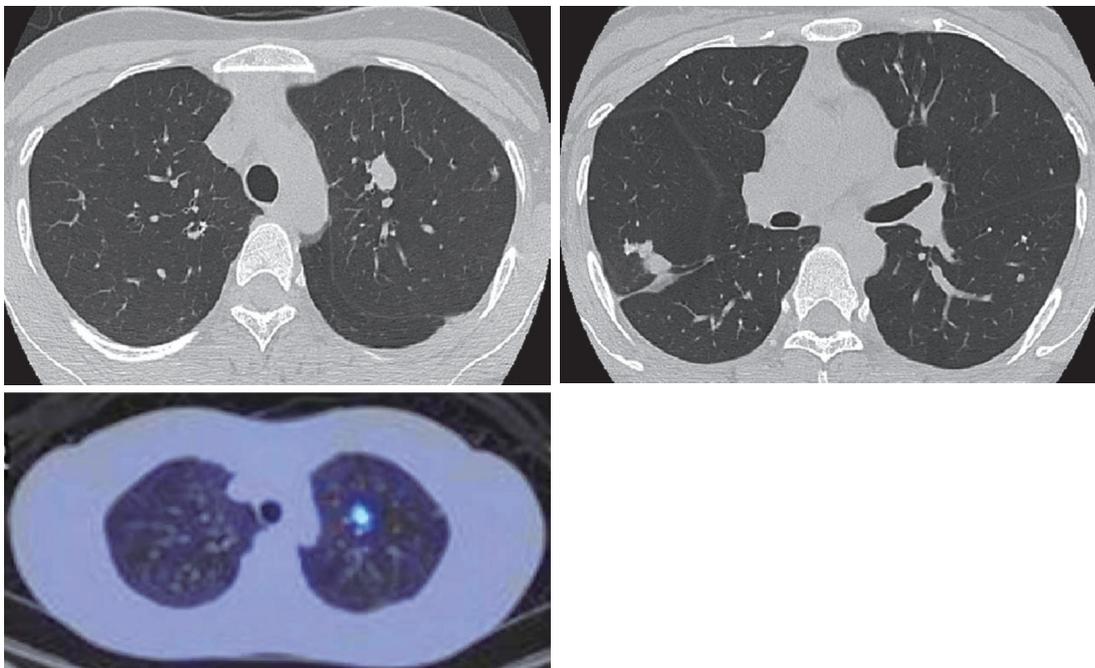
(a) and (b) Conventional CT scan 10 years after diagnosis. (c) FDG-PET scan overlapped with conventional CT scan. Although most of the lung nodules have not changed in size, the two shown here are enlarged. One nodule located in the left upper lobe showed a significant FDG uptake at the maximum of SUV 4.7.
